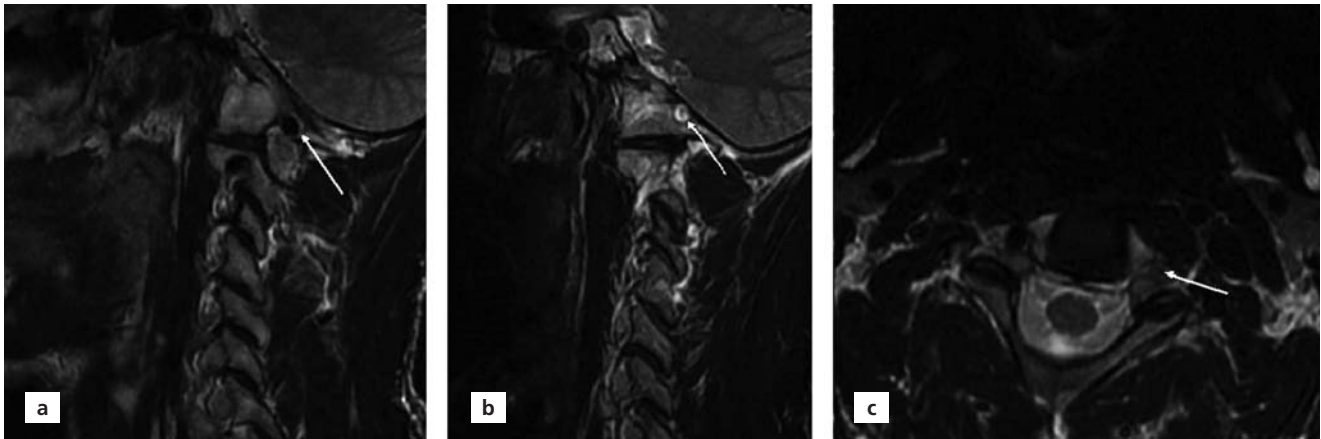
A 38-year-old male with AOA. (a) Right vertebral artery (arrow) coursing in the bony tunnel is seen on sagittal T2-weighted MR image. (b) Sagittal T2-weighted MR image shows empty bony tunnel (arrow). (c) T2-weighted MR image shows empty transverse foramen on the left suggesting agenetic left vertebral artery.
